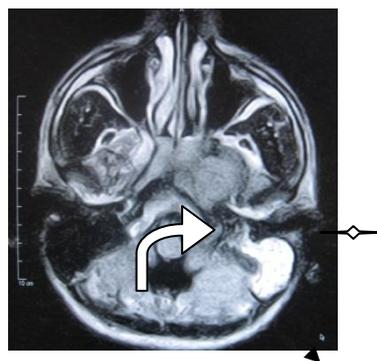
Axial T2 weighted MRI showing the tumour infiltrating the left retro-pharyngeal space with obstructive effusion in the left mastoid sinus
